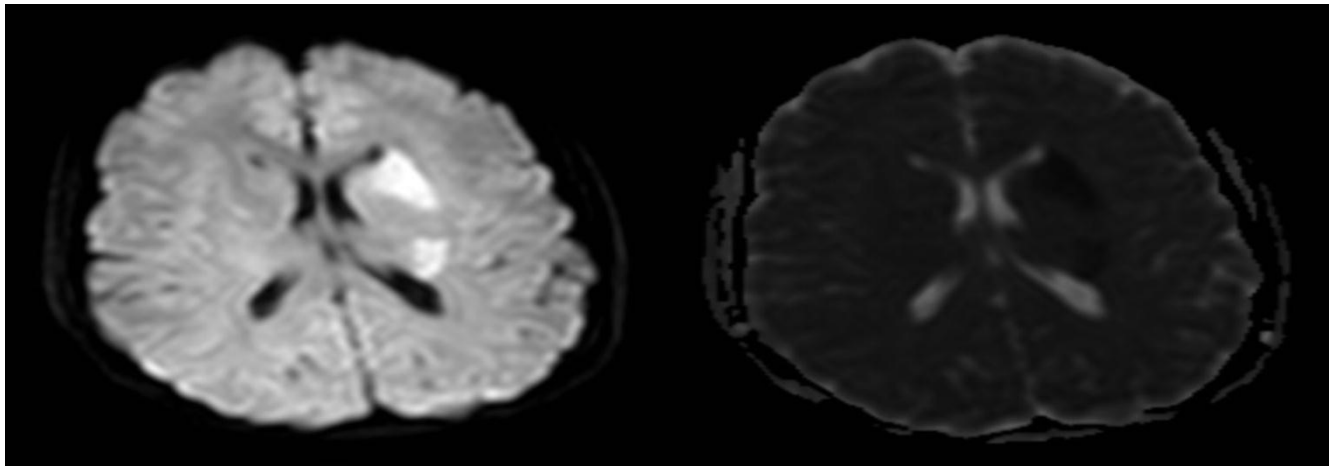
Pre-treatment MRI showing acute ischemic brain territory with a systematized restriction of diffusion sequence (A) and a correlate decrease of ADC (B).
